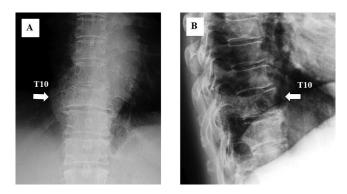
(A). Preoperative anterior-posterior radiograph shows a compressive deformity of the T10 vertebra (arrow) with obscurity of the shape of the right pedicle. (B). Preoperative lateral radiograph shows the T10 vertebral column (arrow) with heterogeneous sclerosis.
